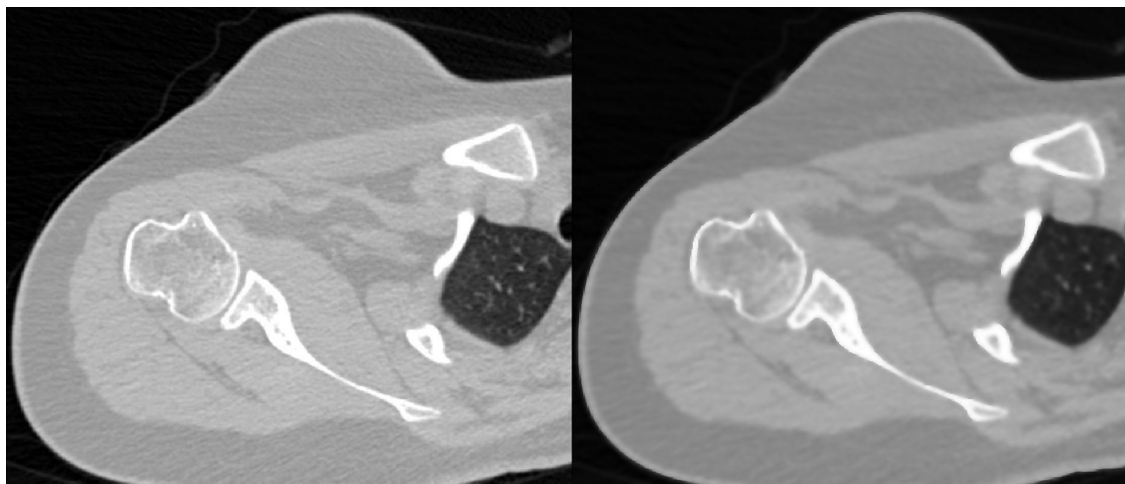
Left, the original image form a CT scan of a shoulder joint, Right, gradient anisotropic diffusion filter applied with 20 iteration.
